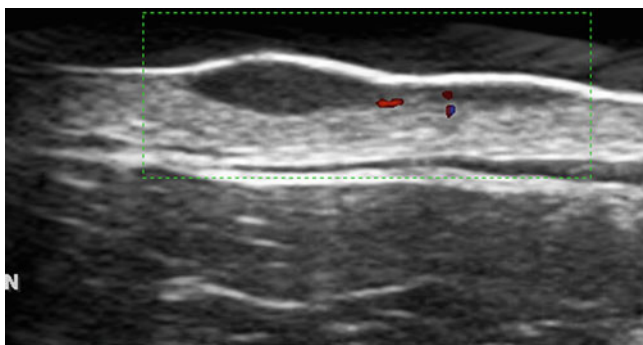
Primary melanoma of the shoulder. Image taken with a gel pad spacer. Directional power Doppler scan. The bilobated melanoma shows multiple little internal flow signals
